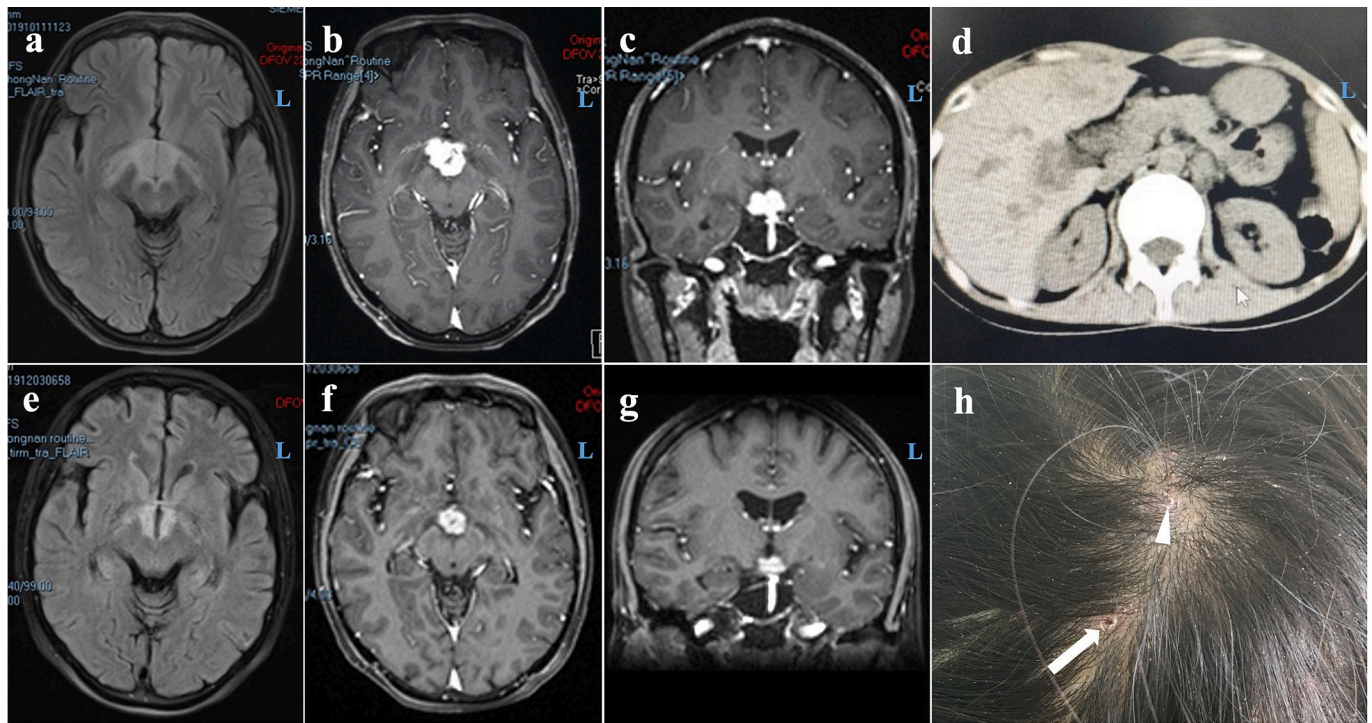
(a ~ c) Brain MRI at baseline showed soft tissue with irregular shape in the sella region, which resulted in mild edema around the lesion (a) and homogeneous enhancement (b, c). (d) Abdomen CT scan revealed a mass lesion with hypodensity in the hepatoportal region. (e ~ g) Post-chemotherapy brain MRI showed alleviation of the hypothalamic mass lesion. "L" indicates left side. (h) The patient underwent a biopsy of the scalp rash. Arrow head indicated the rash. Arrow indicated crusted papula after biopsy.
